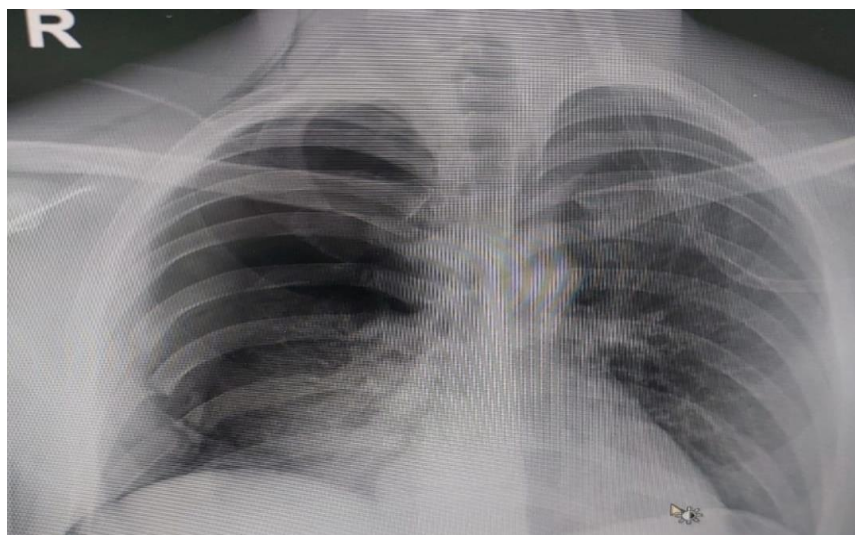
The preoperative X-ray shows multiple displaced right-sided rib fractures with chest wall deformity and reduced right lung aeration, suggesting associated contusion or collapse. No major mediastinal shift or large pleural effusion is evident. Overall, findings indicate significant right-sided thoracic trauma warranting stabilization.
